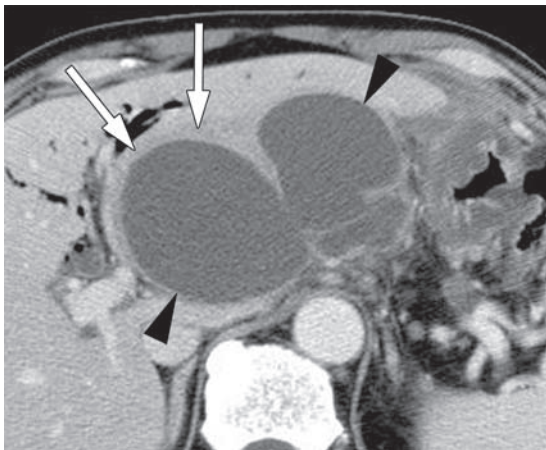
Pseudolesion due to compression by a pseudocyst in a 63-year-old man. Portal venous phase CT scan shows a bandlike low-attenuation area in the subcapsular region (arrows) compressed by a pancreatic pseudocyst (arrowheads).
